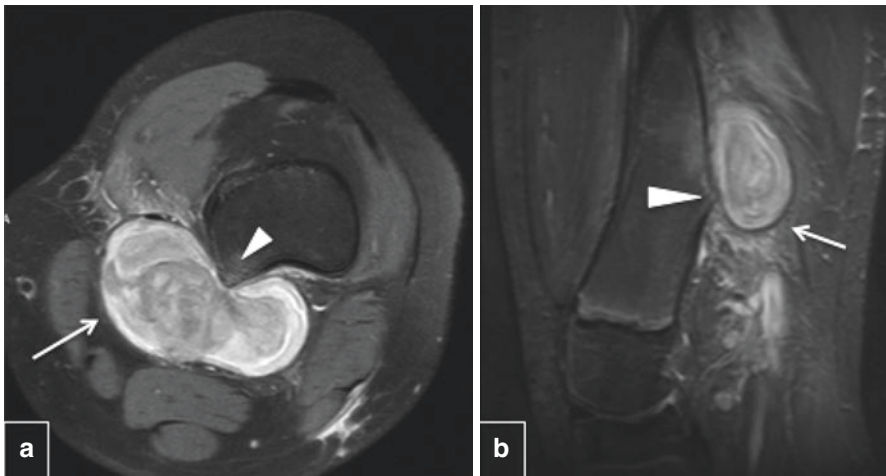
Axial (a) and sagittal (b) MR images demonstrating an osteochondroma (triangle) arising from the distal femur abutting the popliteal artery and causing pseudoaneurysm formation (arrow)
